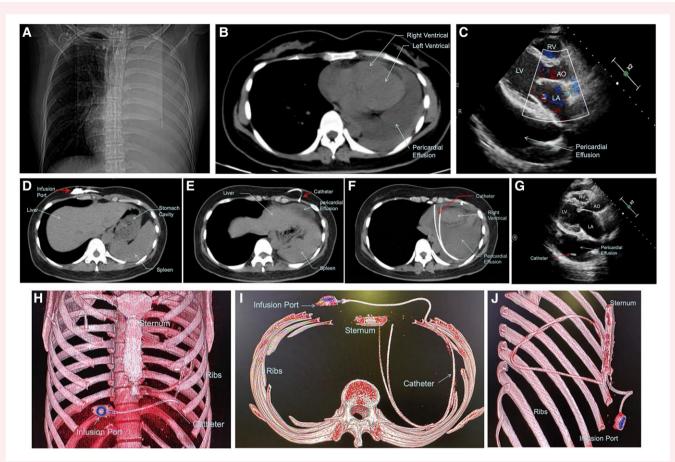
(A) Computer tomography (CT) scout image showed there was a large patchy high-density shadow in the left lung. The left hilum and costophrenic angle were not clear, and the heart shadow was enlarged. (B–C) CT and transthoracic echocardiography showed a large amount of effusion around the heart. (D–F) CT images showed the infusion port and its catheter. (G) The catheter in the pericardial cavity was visible on ultrasound transthoracic echocardiography (red arrow). (H–J) CT scan provided a 3D reconstruction of the placement of the catheter in the pericardial cavity, showing the complete course of pericardial infusion port.
